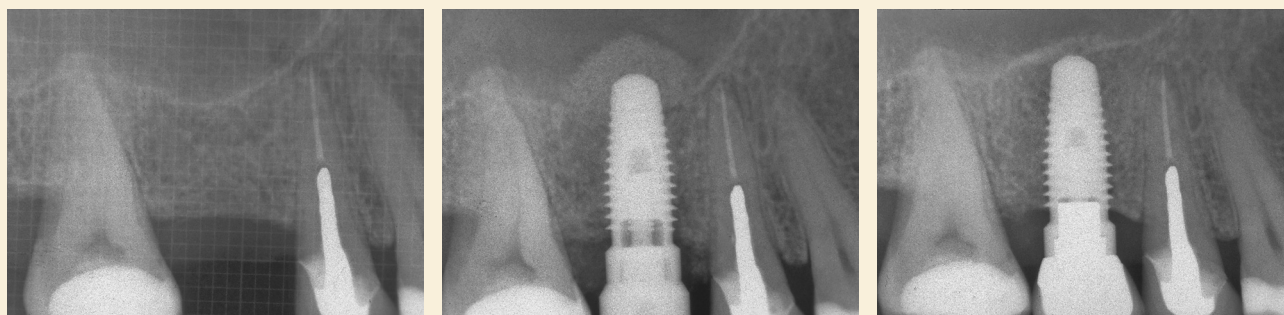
Radiographs of a missing 1.6 with 8 mm of bone. A 10 mm implant is placed with a crestal approach sinus lift using a particulate allograft. Final radiograph is six months later after restoration.
